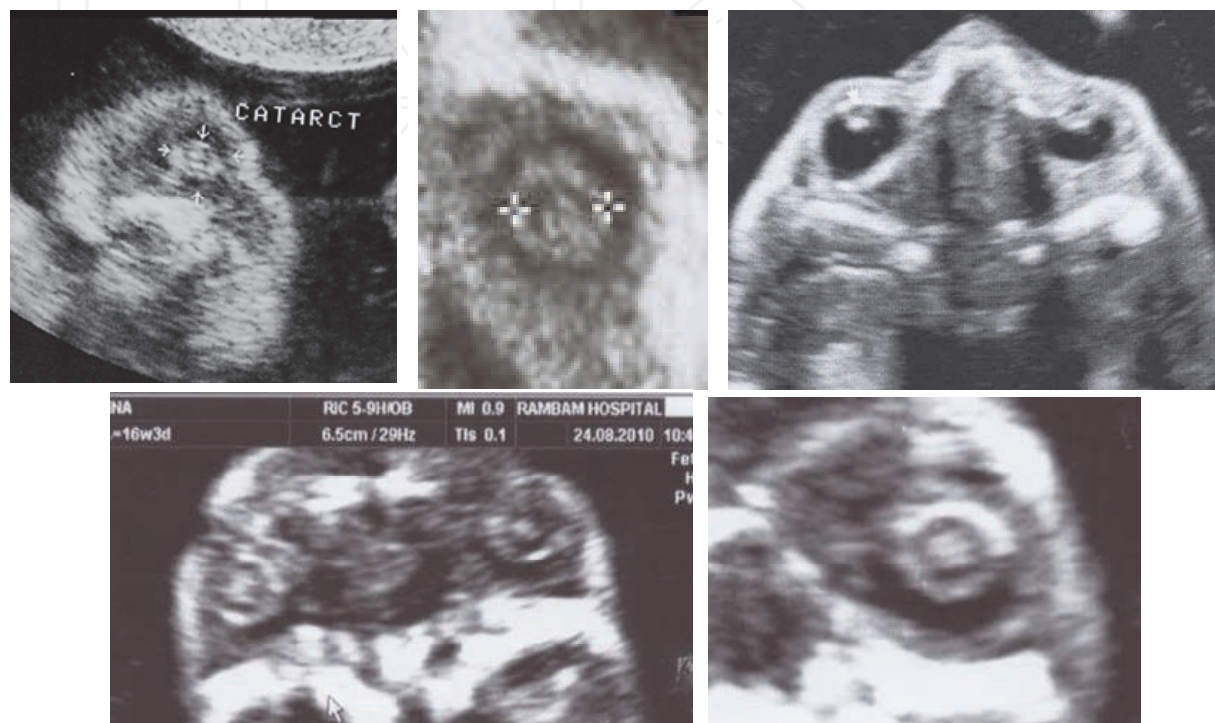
Sonographic pictures of fetal cataracts at 15 weeks of gestation. Coronal views of echogenic lens.
